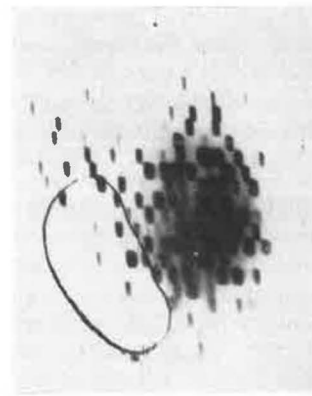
Thyroid clearly revealed by new scintigram method
